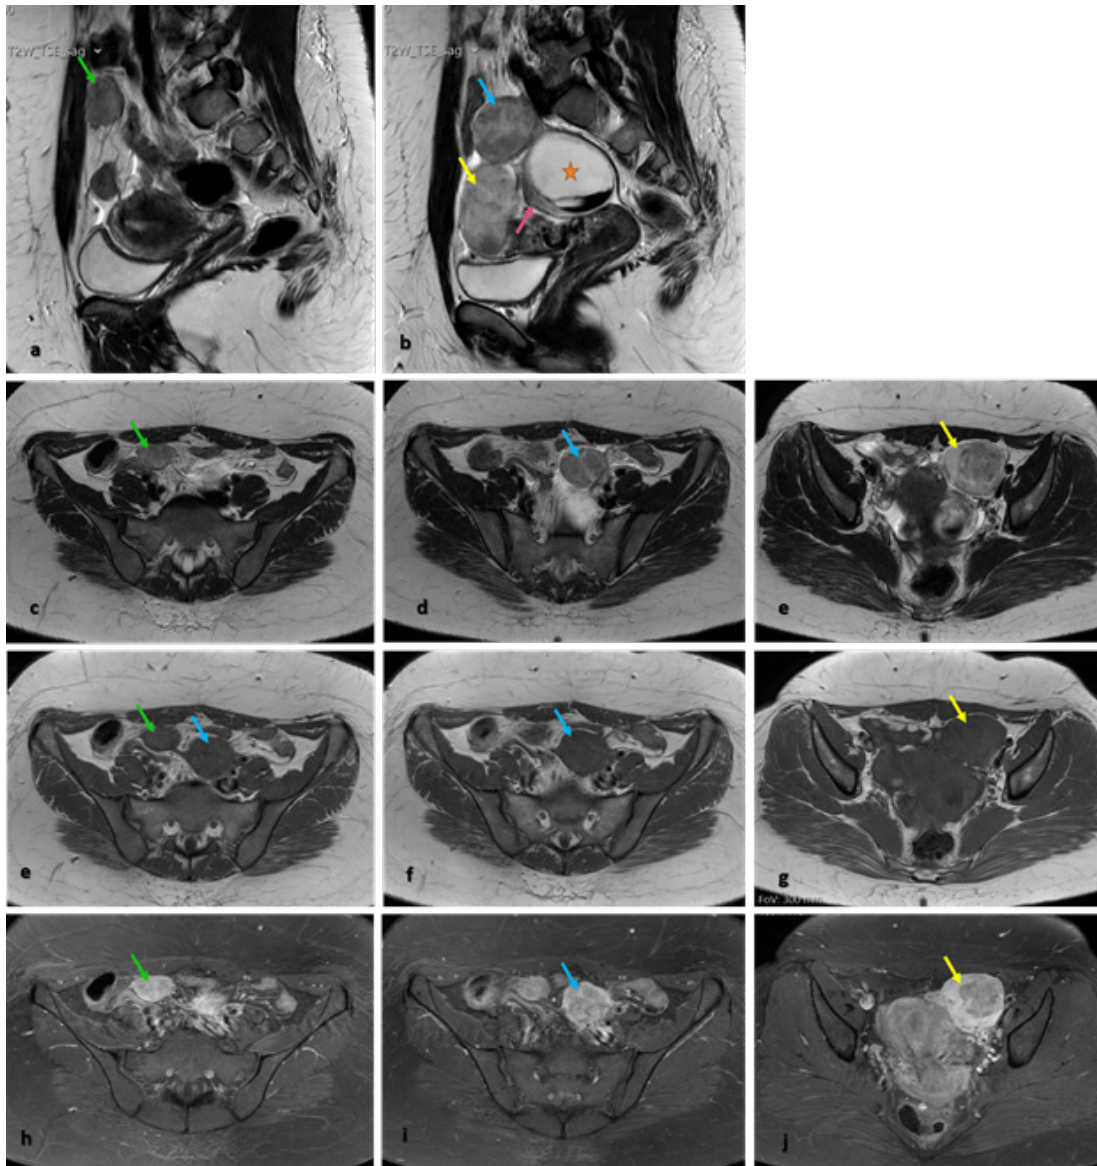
MRI shows three well-defined and heterogeneous tumors, with intermediate signal intensity on sagittal (1a, 1b) and axial (1c-1e) T2WI, and with low signal intensity on T1WI (e-g): one near the left para-uterine margin (yellow arrow), and the other two located superiorly, one on the right (green arrow) and the other more central (blue arrow). Tumors present strong but heterogeneous enhancement on T1W post-contrast image (h-j), particularly the one who was in the left para-uterine region (yellow arrow). There is still a large high signal intensity cystic mass (orange star) with a level formed by a hypointense blood clot in the lower portion; cyst arises from the right ovary (pink arrow) – “positive beak sign” – well seen on sagittal T2WI (1b).
